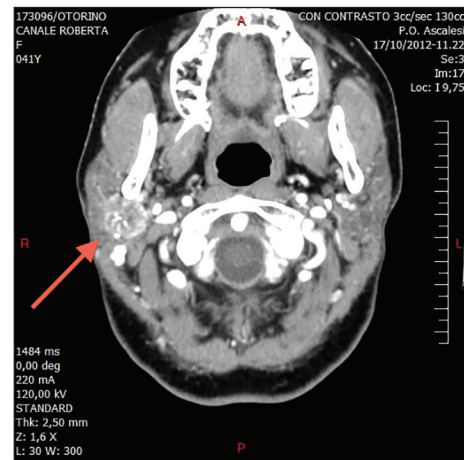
A computed tomography scan shows a non-homogeneously enhancing mass in the right parotid gland
